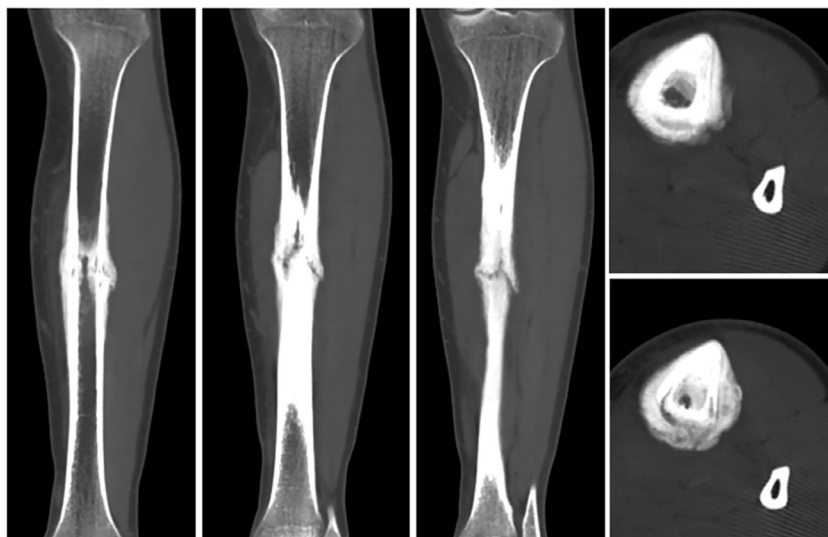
CT Scan of the left tibia.
